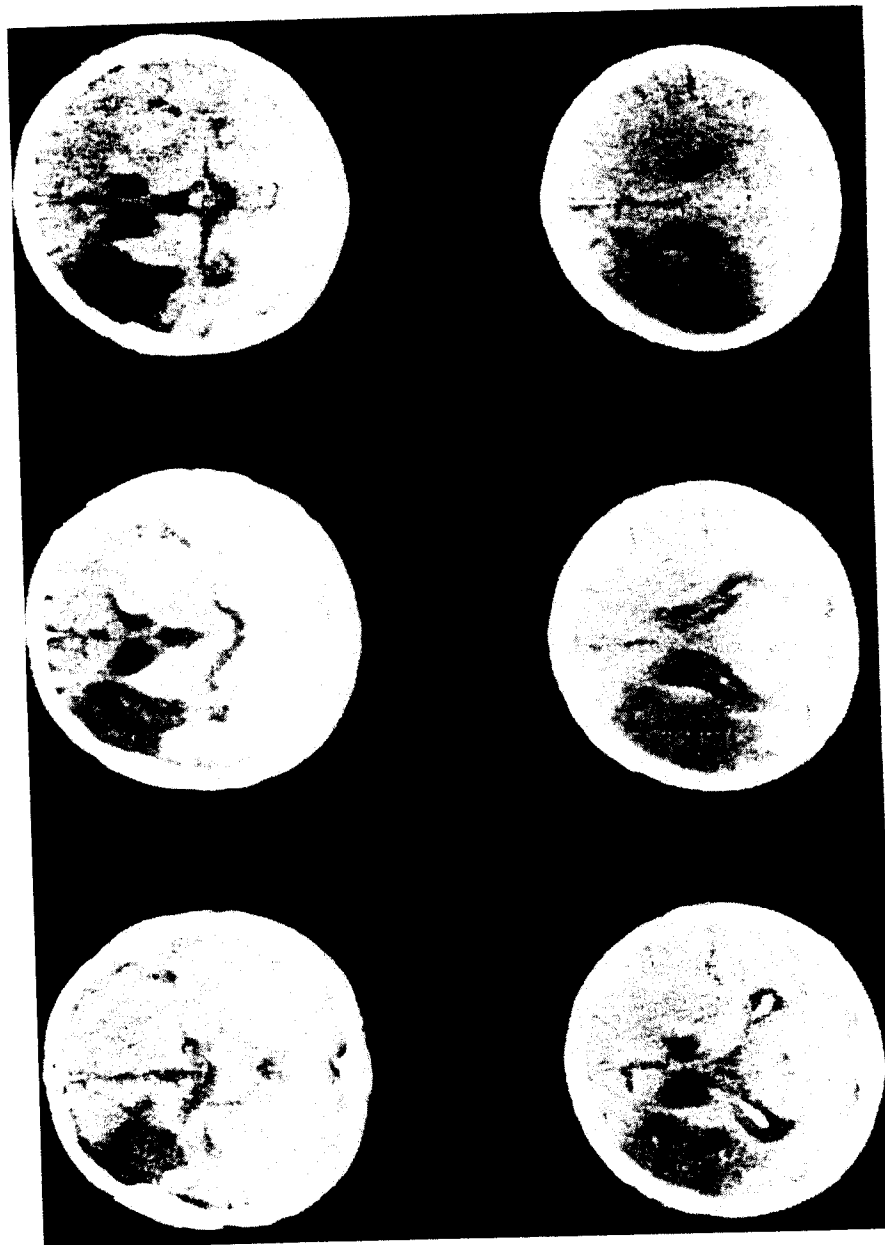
CT scan of an FPTi patient showing cortical lesion in both the frontal and parietal lobes but only subcortical lesion in the temporal lobe, including lesion in the subcortical temporal isthmus.
